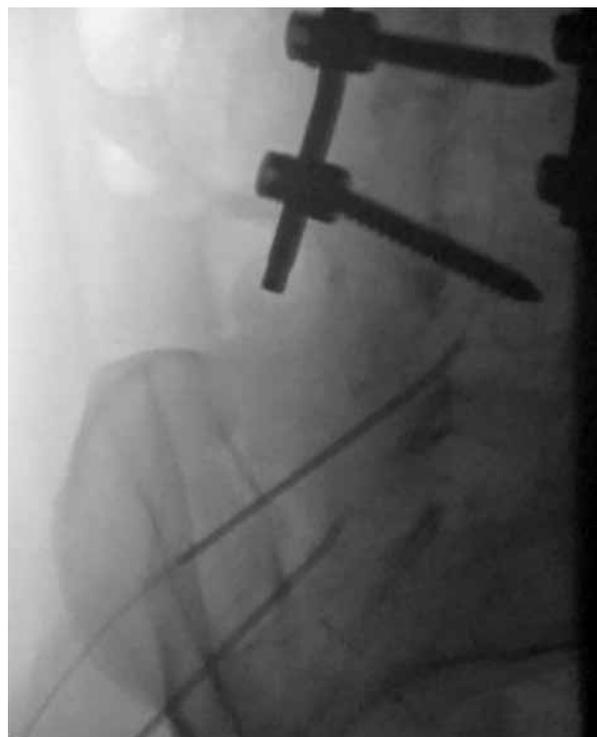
Lateral radiograph demonstrating epidural access at the L4-L5 and L5-S1 disc spaces for spinal cord stimulator trial lead placement.
